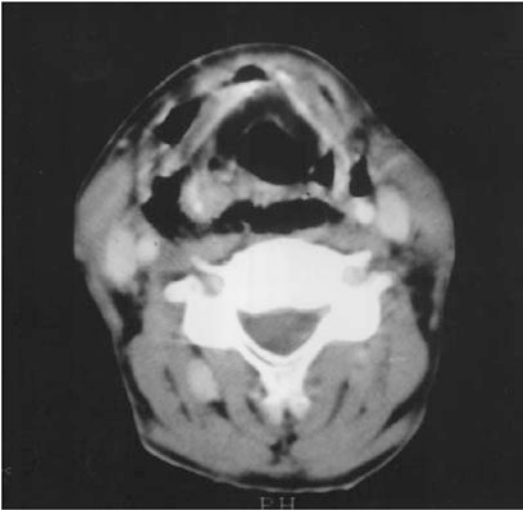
Contrast-enhanced computed tomography scan of the neck in patient with Lemierre's syndrome. Gas is present within the anterior neck compatible with infection with gas-forming organisms. There is also a retropharyngeal space abscess. (Reproduced from Karkos PD, Karkanevatos A, Panagea S, Dingle A, Davies JE. Lemierre's syndrome: how a sore throat can end in disaster. *Eur J Emerg Med* 2004;11:228–30 [39], with permission from Wolters Kluwer Health)
